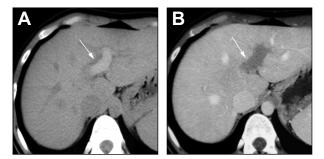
CT scan in a patient with acute symptomatic left portal vein thrombosis. (A) Hyper-attenuation of the left portal vein lumen on unenhanced CT scan (arrow) corresponding to the recent thrombus. (B) There is a lack of enhancement of the left portal vein lumen on portal phase CT scan (arrow), corresponding to the recent thrombus.
